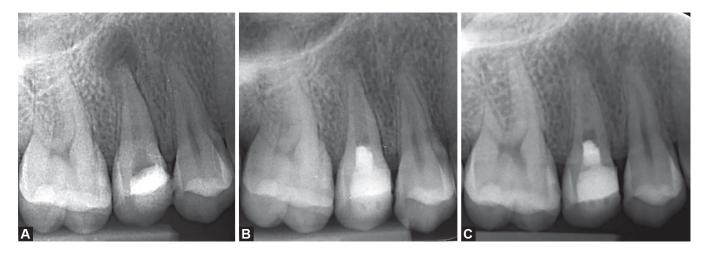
to C: (A) Radiograph following gutta-percha removal of non-vital 15; (B) Postoperative radiograph at 1-year interval presenting vital tooth w.r.t. 15; (C) Two-year interval presenting with primary, secondary, and tertiary healing of 15.
